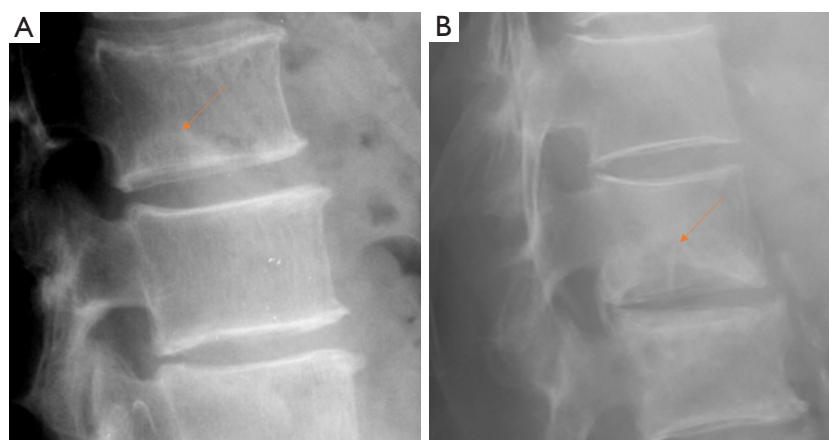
Radiograph of SN type-3 at L2 lower endplate and L3 upper endplate. Arrow shows apparent reactive bone changes while without endplate depression. The location of these two SN is typical of SNd, but the apparent reactive bone changes suggest involvement of acquired cause. There is also intervertebral disc space narrowing. SN, Schmorl's node; SNd, Schmorl's node of developmental cause.
